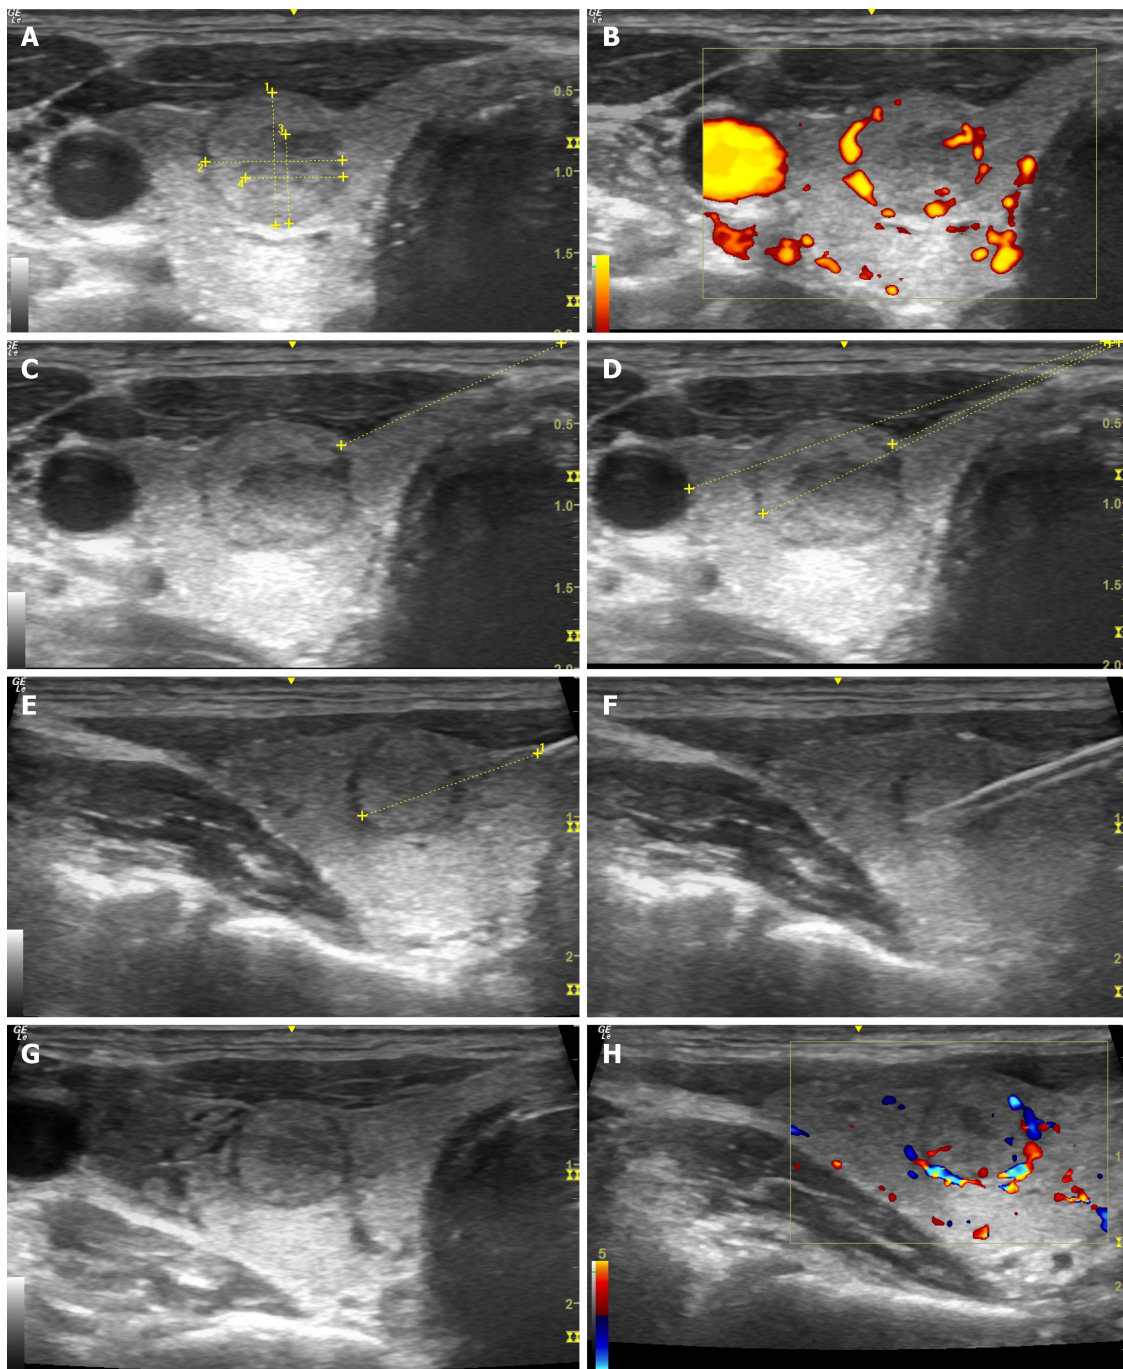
Ultrasonography-guided core-needle biopsy of the thyroid gland. A: Assessment of the size of the mass; B: Assessment in the Doppler mode; C: Marking the optimal trajectory for core-needle biopsy (CNB); D: Calculation of the distance till the mass and major vessels; E: Control of the needle along its length; F: Control during the biopsy; G: Assessment of the mass after CNB; H: Assessment of the node in Doppler mode after CNB.
